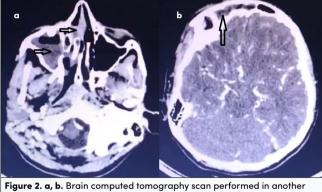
a, b. Brain computed tomography scan performed in another hospital. (a) Collection of dense fluid in compliance with rhinosinusitis in the right ethmoid and maxillary sinus (black arrows). (b) Collection of dense fluid in compliance with rhinosinusitis in the right frontal sinus (black arrow)
